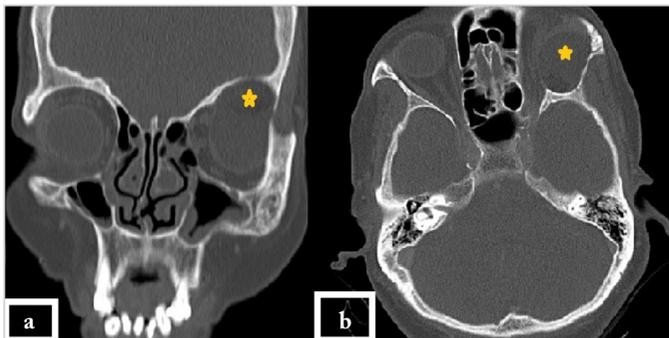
Preoperative computed tomography scan of the patient depicting the cyst location (yellow asterisk) within the intraorbital compartment. a) Coronal view, and b) Axial view
